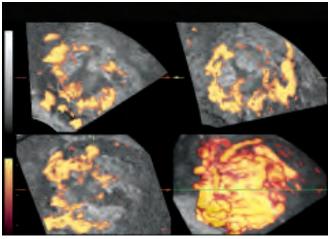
Orthogonal three planes of 2D power Doppler showed clear molar vesicles and the 3D power Doppler showed rich intreuterine blood flow of various directions. There was no image of the fetus or fetal blood flow or any fetal particle through all images of these Doppler studies *Courtesy:* G Varga
